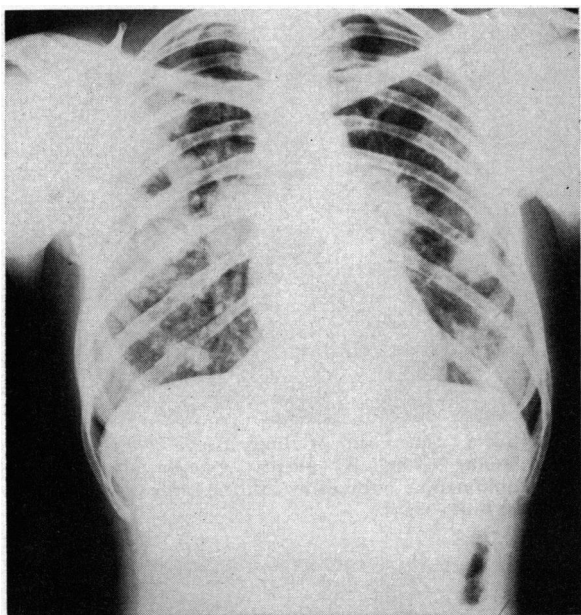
Routine chest roentgenogram obtained on May 29, 1959, two days before admission to the hospital, showing extensive and diffuse bilateral granulomatous infiltrate. The patient was asymptomatic.
